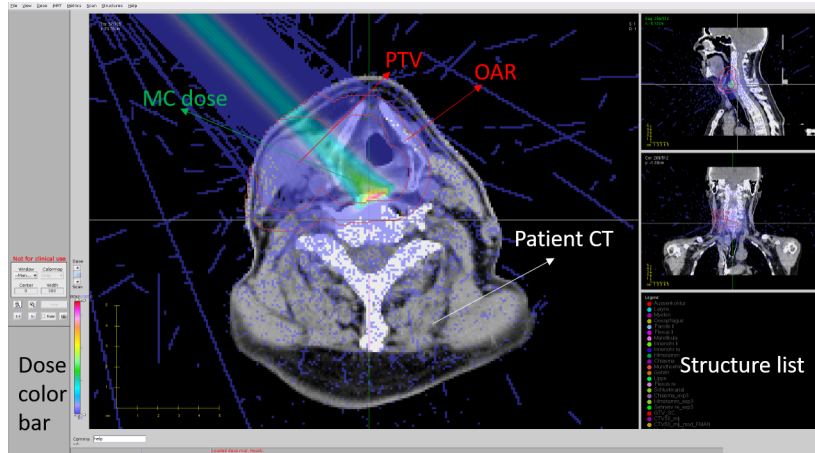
The interface of CERR TPS. The patient CT, organ contouring (in this example the PTV TP OAR of H&N1) and exemplary PB MC dose used for the MC TP optimization process are shown.
